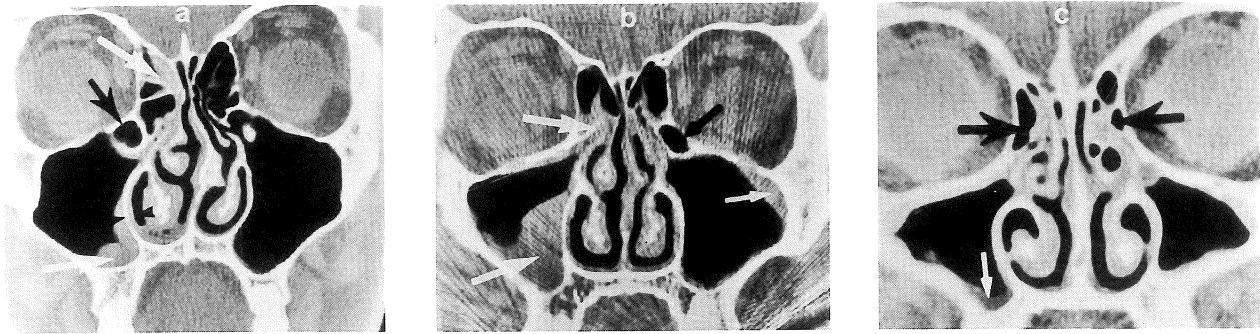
Sinus CT scans of three patients with early common colds show examples of the irregular distribution of sinus-cavity abnormalities in cases of viral rhinosinusitis. In *a*, there are abnormalities in the right maxillary and ethmoid sinus cavities (white arrows) but none on the left. A large infraorbital ethmoid cell (Haller’s cell) is present on the right (black arrow). In *b*, moderate to marked abnormalities are evident in the right maxillary and ethmoid sinus cavities (large white arrows), with minimal abnormality in the left maxillary sinus cavity (small white arrow). A large infraorbital ethmoid cell (Haller’s cell) is present on the left (black arrow). In *c*, bilateral ethmoid sinus abnormalities (black arrows) can be seen, with minimal abnormality in the right maxillary sinus cavity (white arrow).
